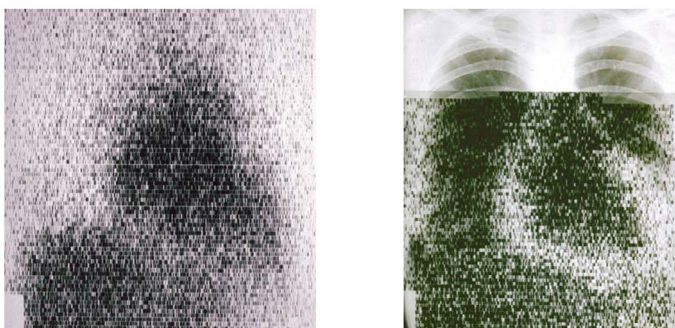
Blood pool scintigraphy using RISA (^{131}I -Human Serum Albumin) (left) and $^{99\text{m}}\text{Tc}$ -Alubumin overlapped on X-ray photo showing cold halo surrounding the hot blood pool in a patient with pericardial effusion (right) (Color online).
